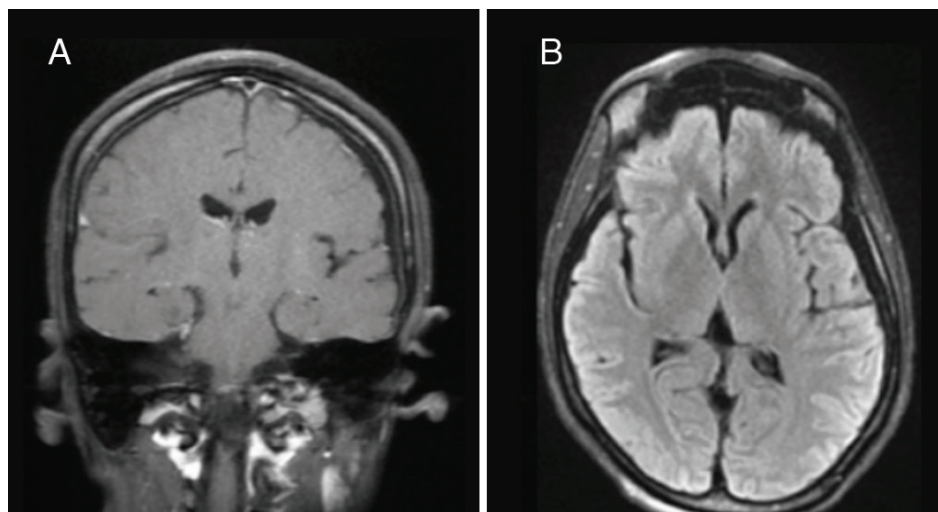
No parenchymal lesion or contrast enhancement is observed in (A) C+T1 coronal and (B) FLAIR axial sequences
